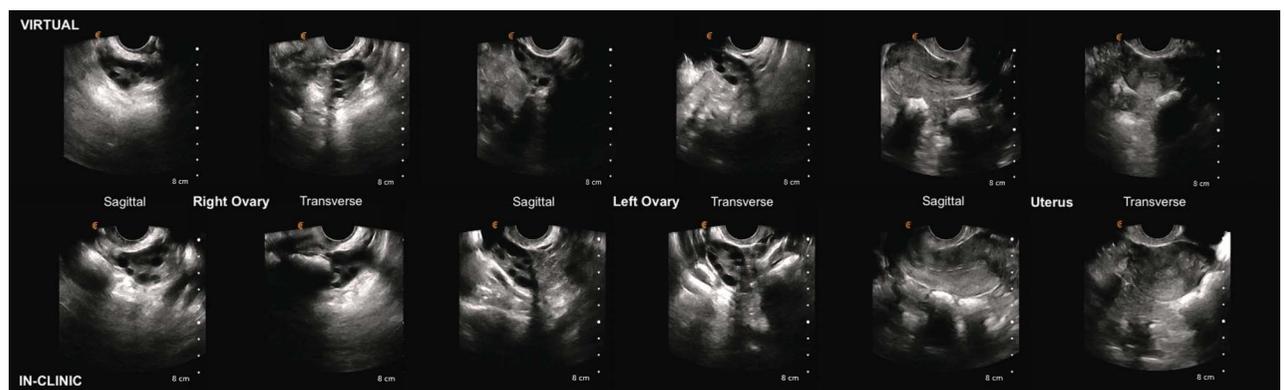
Representative image panel of virtual and in-clinic cine clips of the right ovary, left ovary, and uterus. Chung. *Virtual vs in-Clinic Transvaginal Ultrasonography*. *Obstet Gynecol* 2022.
